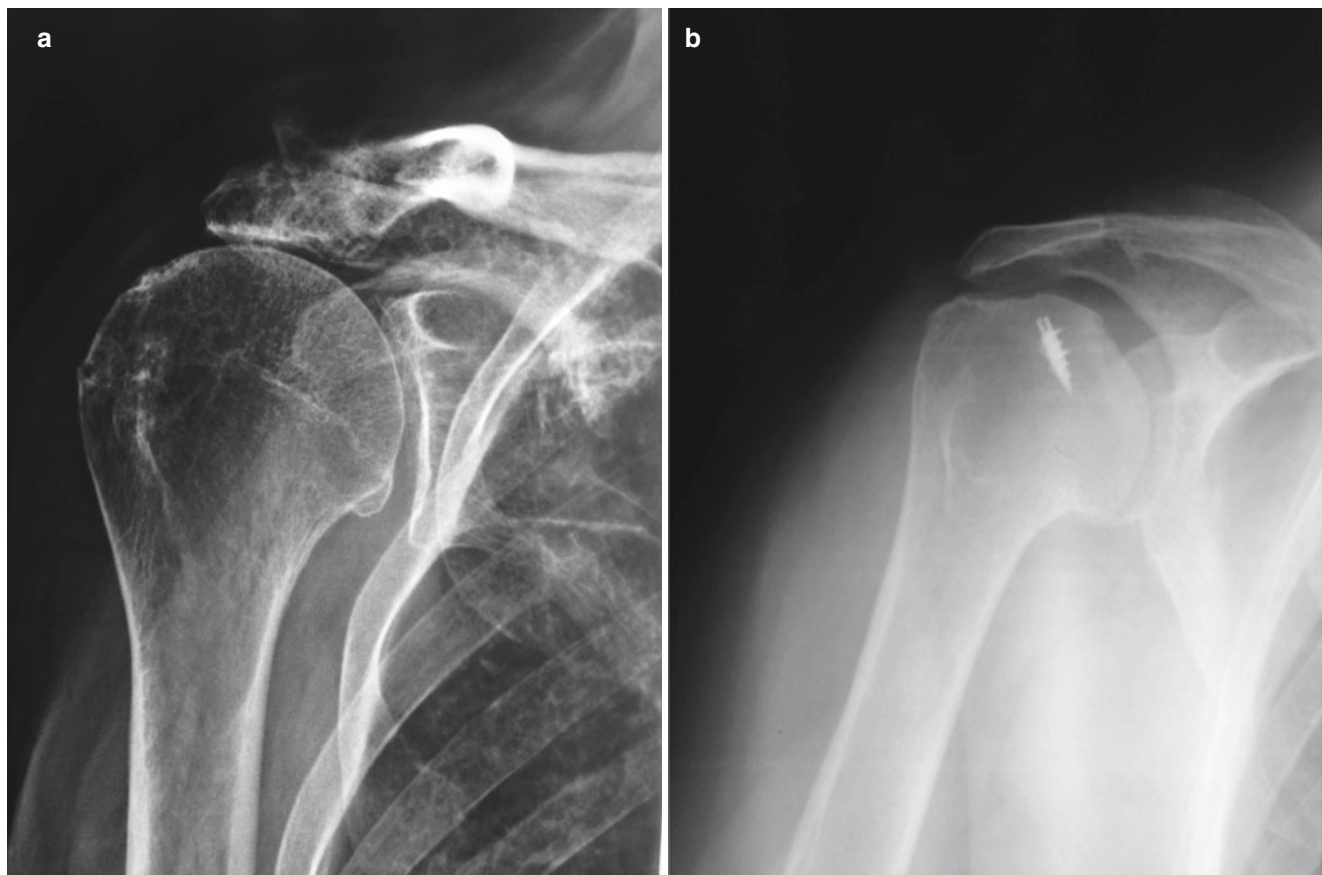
(a) True AP X-ray view of a right shoulder: Hamada 3 cuff tear arthropathy. (b) AP X-ray view of a right shoulder: Hamada 5 cuff tear arthropathy, bony destruction – humeral head collapse after a cuff repair failure
